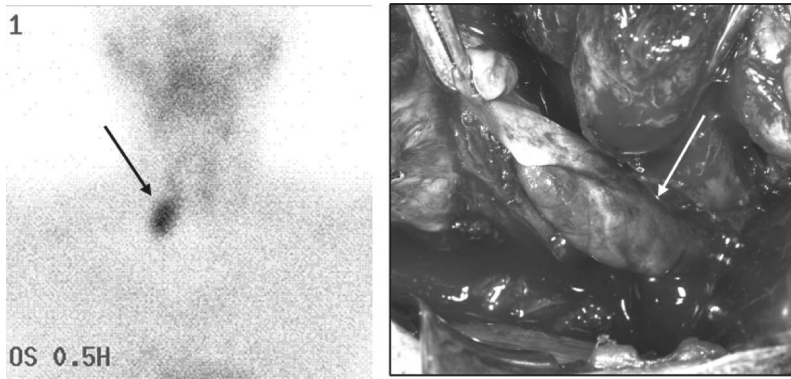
Positive Tc99m-MIBI-SPECT imaging scan demonstrating increased radioactive pharmaceutical uptake in the right lower neck suggesting a pathological parathyroid gland in this location (A), concurring with subsequent operative findings of a 2,5 cm pathological parathyroid adenoma (B).
